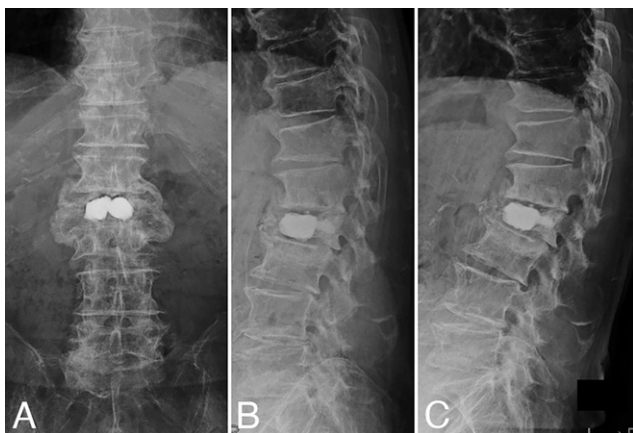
Postoperative radiological findings 14 months after BKP in the supine position (A), lateral position (B), and sitting position (C). Postoperative radiography demonstrated a massive bridging callus and well-stabilized affected vertebra with signs of radiographic bony union.
